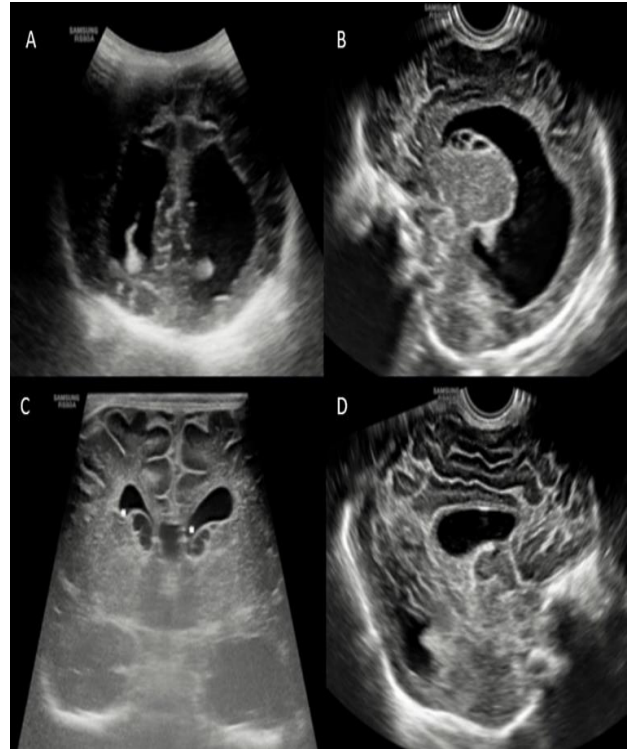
Transcranial B-mode ultrasound of neonatal brain in coronal section (A) and parasagittal section (B) shows dilated lateral ventricle. (C) Subependymal germinolytic cysts (solid arrows) are noted bilaterally. (D) Sagittal section shows thinned-out corpus callosum.
